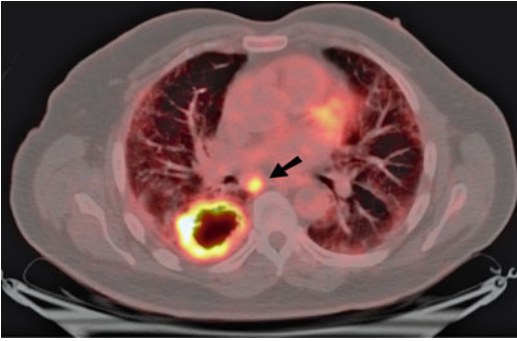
Preoperative staging non-small cell lung cancer with FDG PET. A 67-year-old man with pulmonary fibrosis underwent a staging FDG PET-CT scan for newly diagnosed moderately differentiated squamous cell carcinoma of the right lung. On PET-CT, the primary mass in the right lower lobe measured 57 mm with a rim of intense FDG uptake ($SUV_{max} = 18$) and central photopaenia consistent with necrosis. There was focal intense uptake within a 24 mm subcarinal lymph node with a SUV_{max} of 12 (arrow) consistent with metastatic disease which was confirmed and resected during surgery
